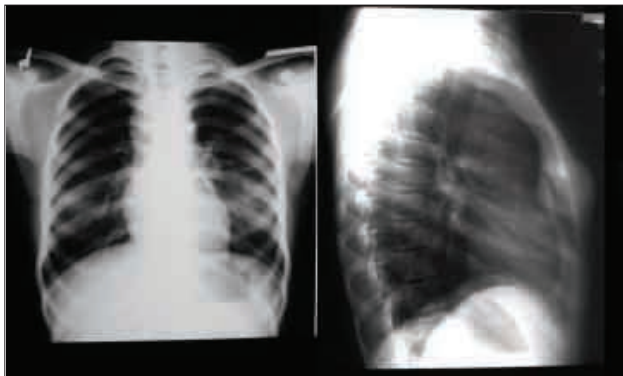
Plain chest radiographs.
